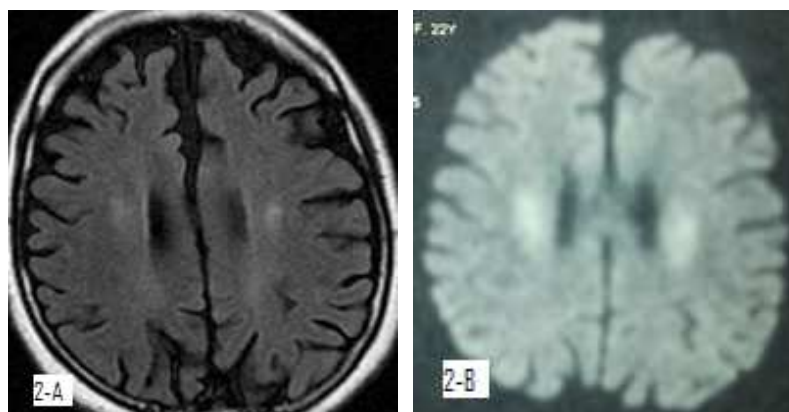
A. Flair brain magnetic resonance imaging (MRI) showed two hyperintense periventricular lesions; B: Diffusion weighted imaging recovered restriction
